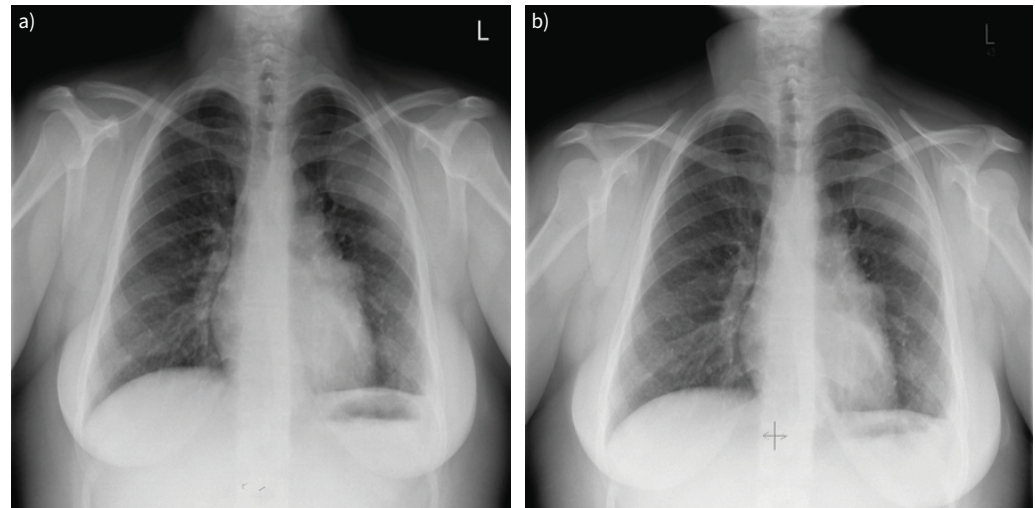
Chest radiographs in a) 2016 and b) 2019. Left upper lobe and hilar based masses are unchanged over 3 years of follow-up.
